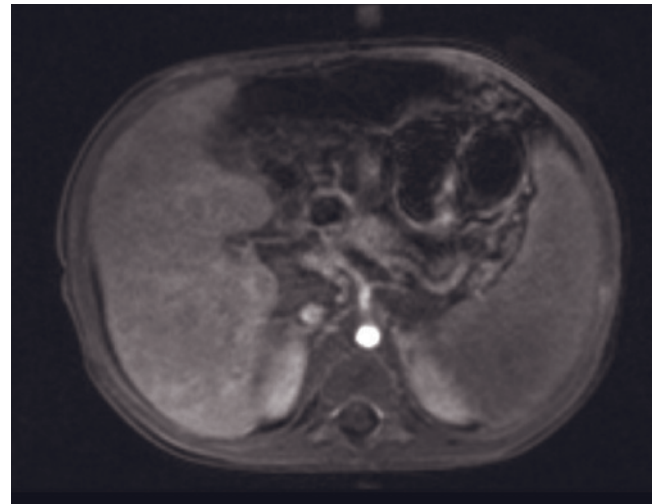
Breathing-averaged (sedated patient) protocol in an 13-month-old female at 3.0 T. Coronal T2-weighted single-shot echo-train spin-echo (a), axial T2-weighted single-shot echo-train spin-echo (b), axial T1-weighted MR-RAGE (c), axial T1-weighted water-excitation MP-RAGE (d), coronal T1-weighted 90-s postgadolinium fat-suppressed 3D-GE(e), axial T1-weighted water-excitation MP-RAGE postgadolinium (f) images of a 13-month-old female with hepatoblastoma. The breathing motion artifact is minimal when such a protocol is observed while using 3.0 T systems.
